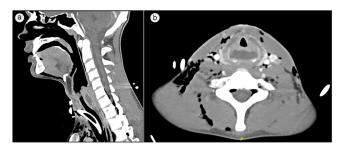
Soft tissue neck CT with contrast. (a) Sagittal and (b) axial images showing a $2.7 \times 1.0 \times 2.2$ cm fluid collection posterior to the larynx at the glottic and subglottic level.
